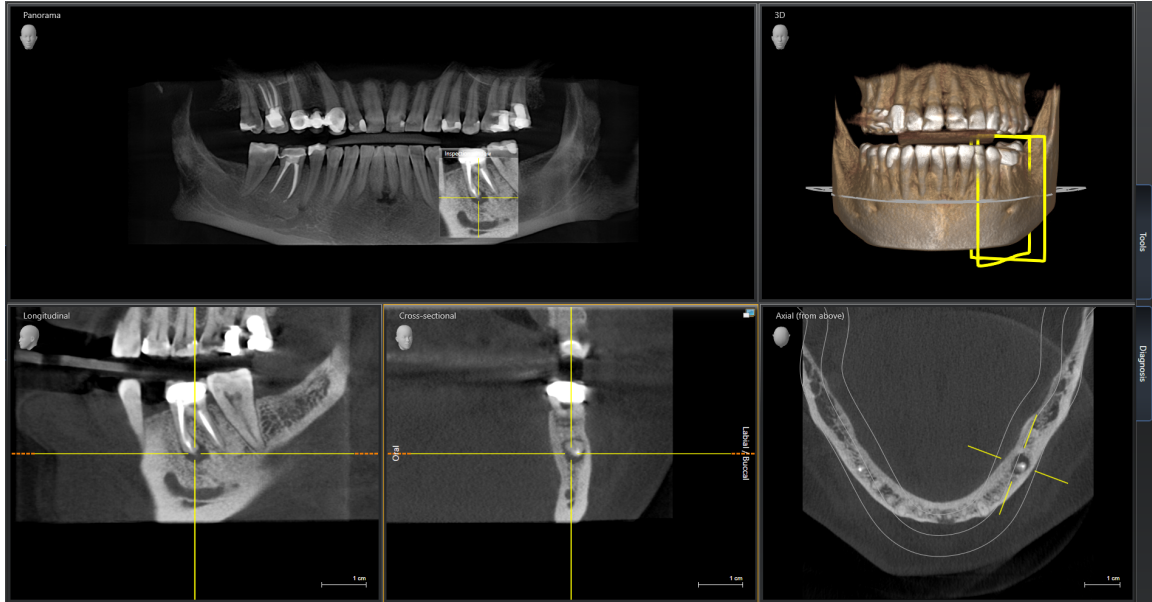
CBCT Lesion Image: This image represents a CBCT lesion of tooth #19, an example of a lesion presented to observers. Observers had full control of all CBCT data and could view all slices of the CBCT.
